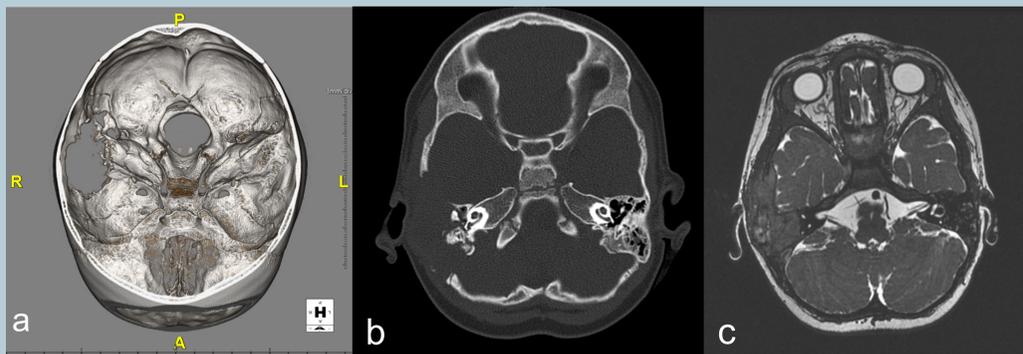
Aggressive right temporal bone lesion a) 3D reconstruction b) axial CT highlighting intracranial extension and zygomatic arch erosion c) MRI brain FIESTA image with demarcation between temporal lobe and mass elucidating intracranial, extracranial extension
